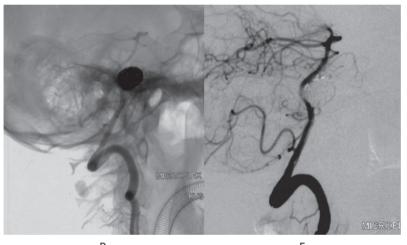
Lower BA trunk berry aneurysm (Case 8). A) CT showing SAH mainly in the ambient cistern. B) CTA showing a fenestration at the lower BA, with the berry aneurysm situated within the fenestration. C) DSA of the aneurysms. D,E) DSA showing occlusion of the BA aneurysm.
